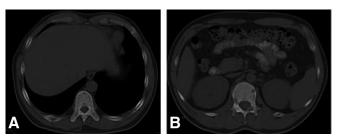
A, Noncontrast CT scan at the level of the thoracic vertebrae shows multiple tumors in the vertebras and ribs, with expansive appearance and ballooning of the thinned cortex. B, Noncontrast-enhanced CT demonstrates a lytic lesion in the right pedicle, lamina of the L1 vertebra.
